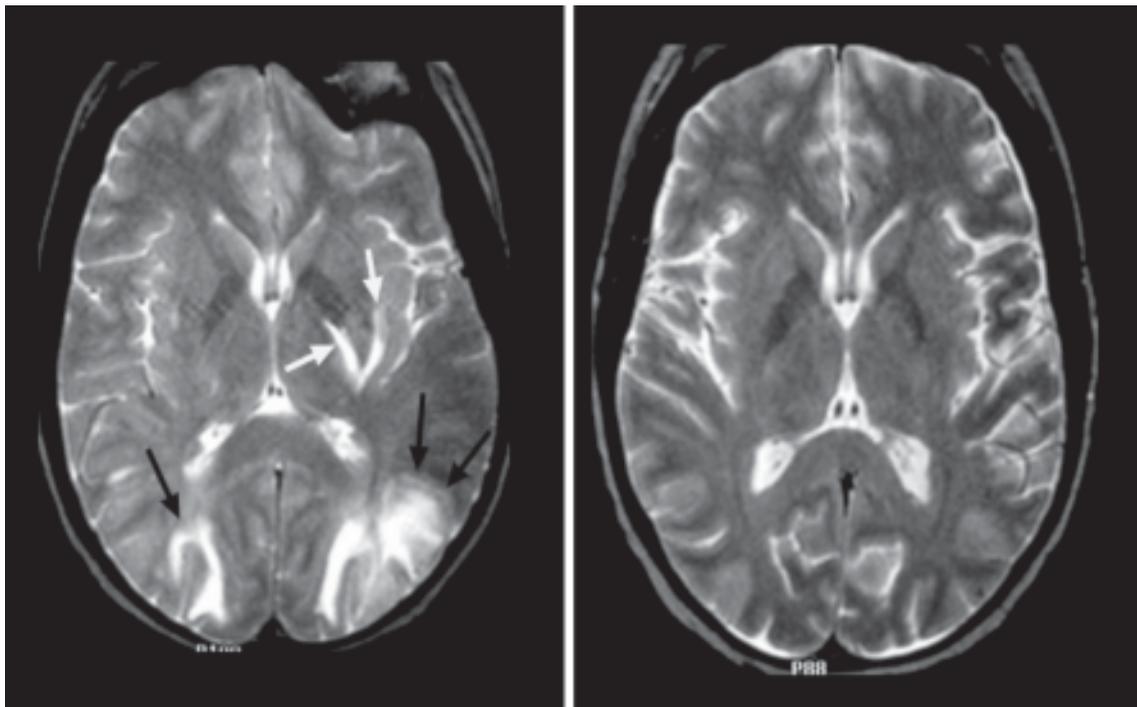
This patient had received Cyclosporine A following bone marrow transplantation. MRI (A) demonstrates T2 hyperintensity in the occipital lobes (black arrows) and left internal/external capsules (white arrows). Following discontinuation of the Cyclosporine A, the symptoms and MR changes reversed (B) (reversible MR changes with Cyclosporine A).
